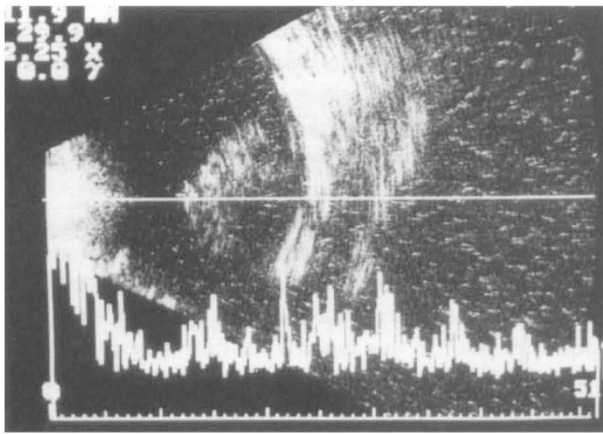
Ultrasonography (B-scan) demonstrating the large raised choroidal mass.
